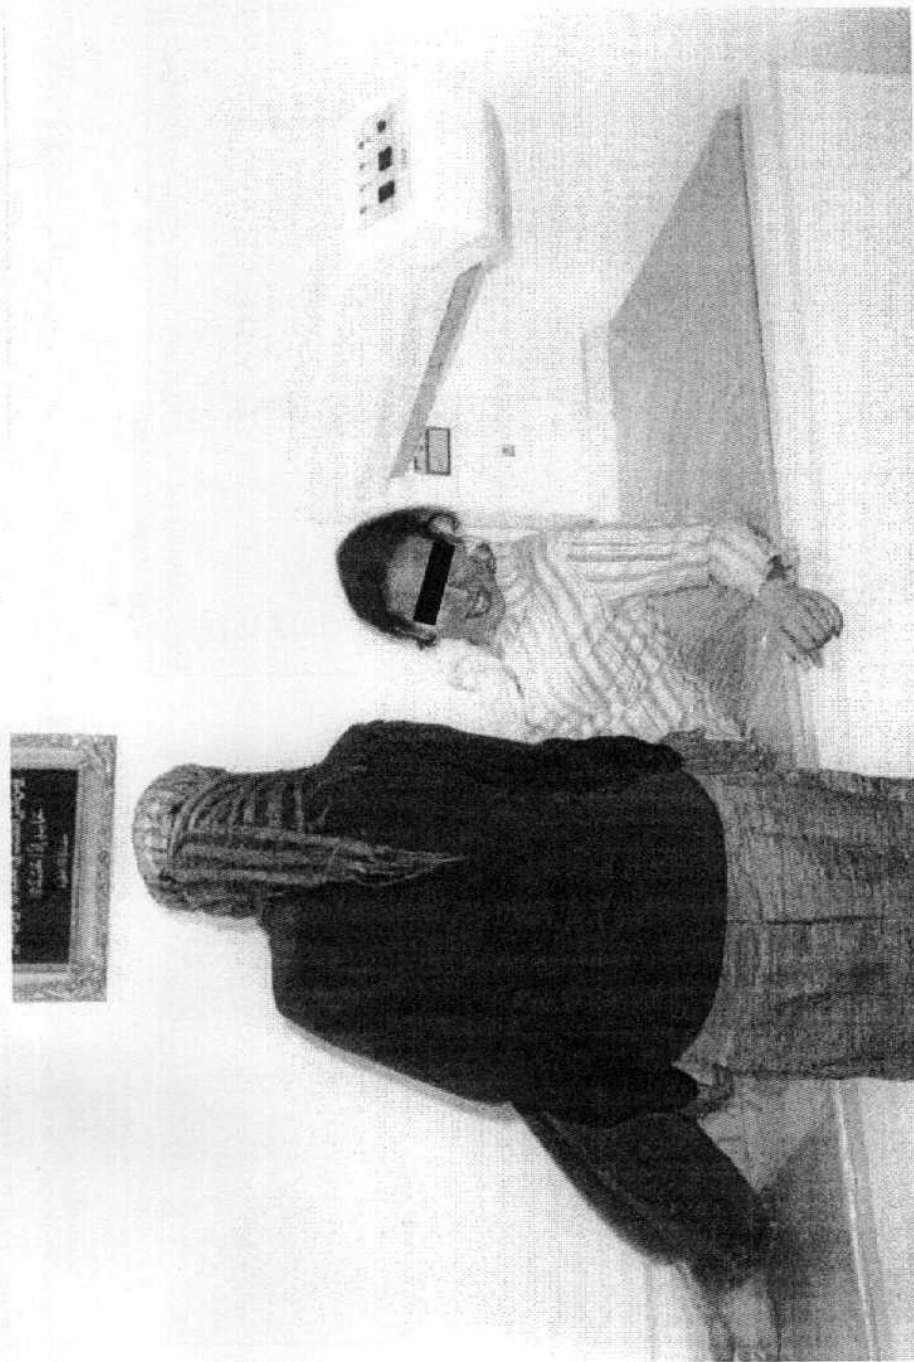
Typical arrangement for a total body scan, for one of the healthy Controls, using the Dual-energy X-ray Absorptiometry (DXA) at the Department of Medical Biophysics, Medical Research Institute, Alexandria University, Alexandria, EGYPT.
